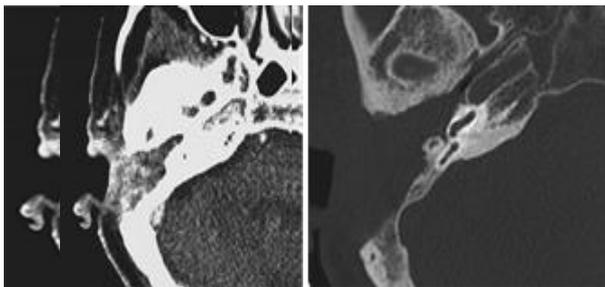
(a) right temporal axial CT scan with soft tissue algorithm showed a non-specific mass. (b) bone algorithm showed that the aggressiveness of mass erodes the mastoid bone and extended to the middle ear
